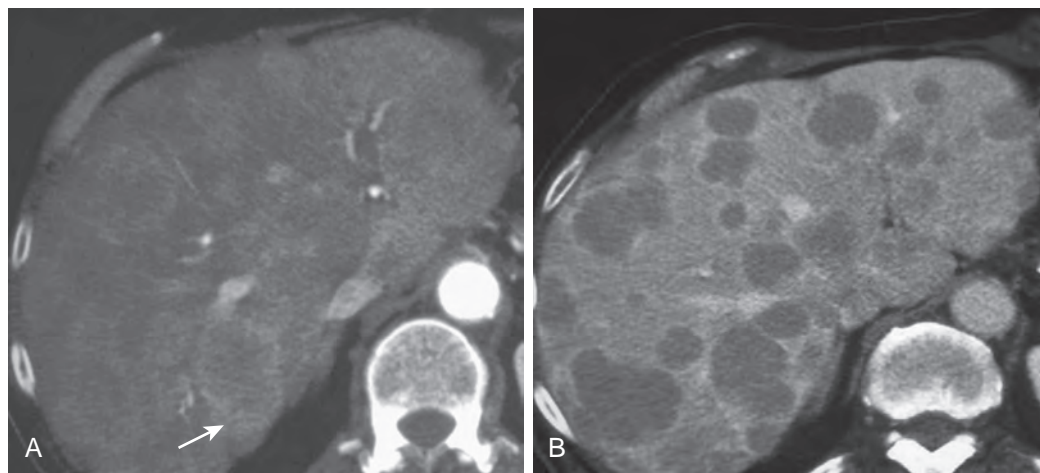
Ring enhancement of liver metastases on CT. Arterial (A) and portal venous (B) phase images show a hypervascular ring of enhancement (arrow). This complete ring of enhancement is typical of metastases but can also be seen in hepatic abscesses.
